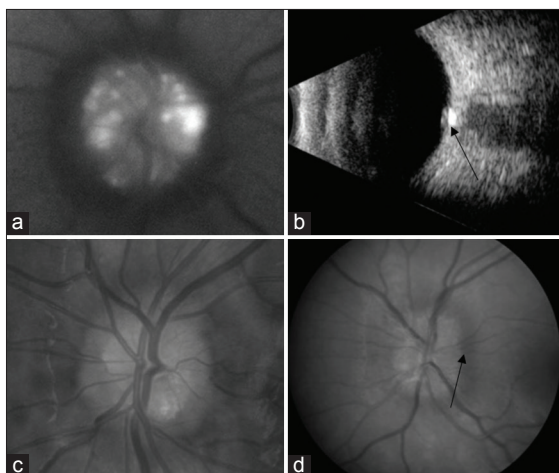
Various imaging modalities demonstrating the presence of optic disc drusen in the pediatric patient. (a) Fundus autofluorescence demonstrating focal hyperfluorescence from drusen. (b) B-scan ultrasonography. Hyperechogenicity at the optic nerve head localizes to the calcified opacities (arrow). (c) Fundus photo with typical “lumpy bumpy” optic disc appearance secondary to multiple drusen. (d) Fundus photo of disc drusen associated with mild optic disc vessel obscuration (arrow), presenting a diagnostic challenge when trying to distinguish between true edema and pseudopapilledema
